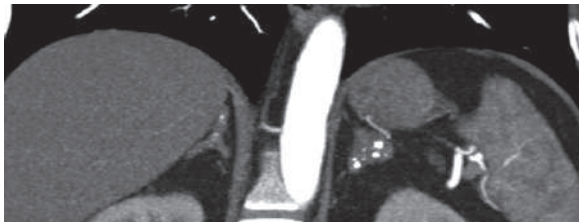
Coronal postcontrast CT image of a patient with Addison's disease (AD) shows bilateral adrenal calcification (classical finding)
